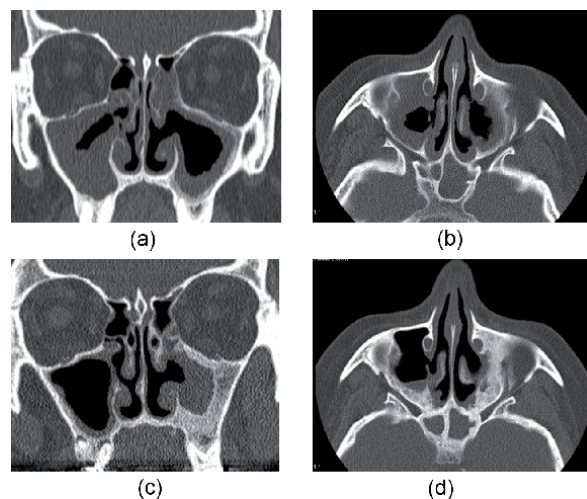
(a) Coronal CT and (b) axial CT in granulomatosis with polyangiitis show status after bilateral endoscopic sinus surgery (media-antrostomy). The bone is thickened due to chronic osteitis. Notice small peripheral rim of osteoneogenesis along the lining of the left maxillary sinus. (c) Coronal CT and (d) axial CT, follow-up CT 5 years later, demonstrate extensive bilateral osteitis of the maxillary and sphenoid sinuses. Notice also the small periapical lucencies around the roots of the right upper molar, often seen in patients with granulomatosis with polyangiitis.
